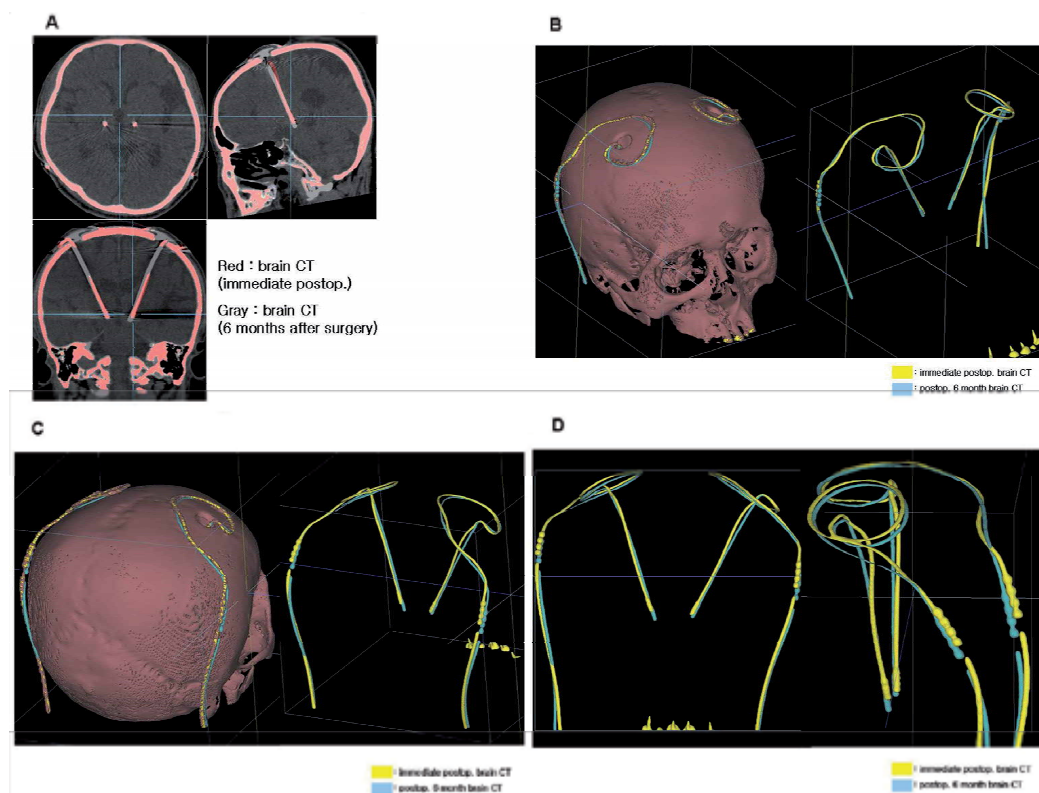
Fused images of an immediate postoperative brain CT and a brain CT taken 6 months after bilateral subthalamic nucleus stimulation.
